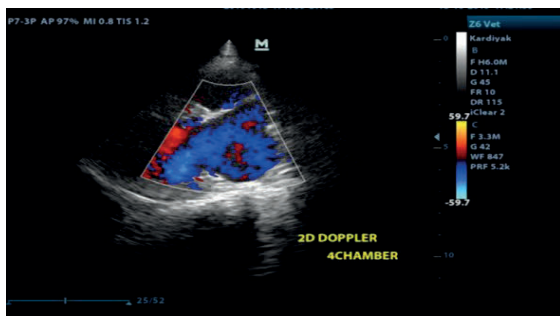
Right Parasternal Long axis 4 Chamber Color Doppler image (normal blood flow).
